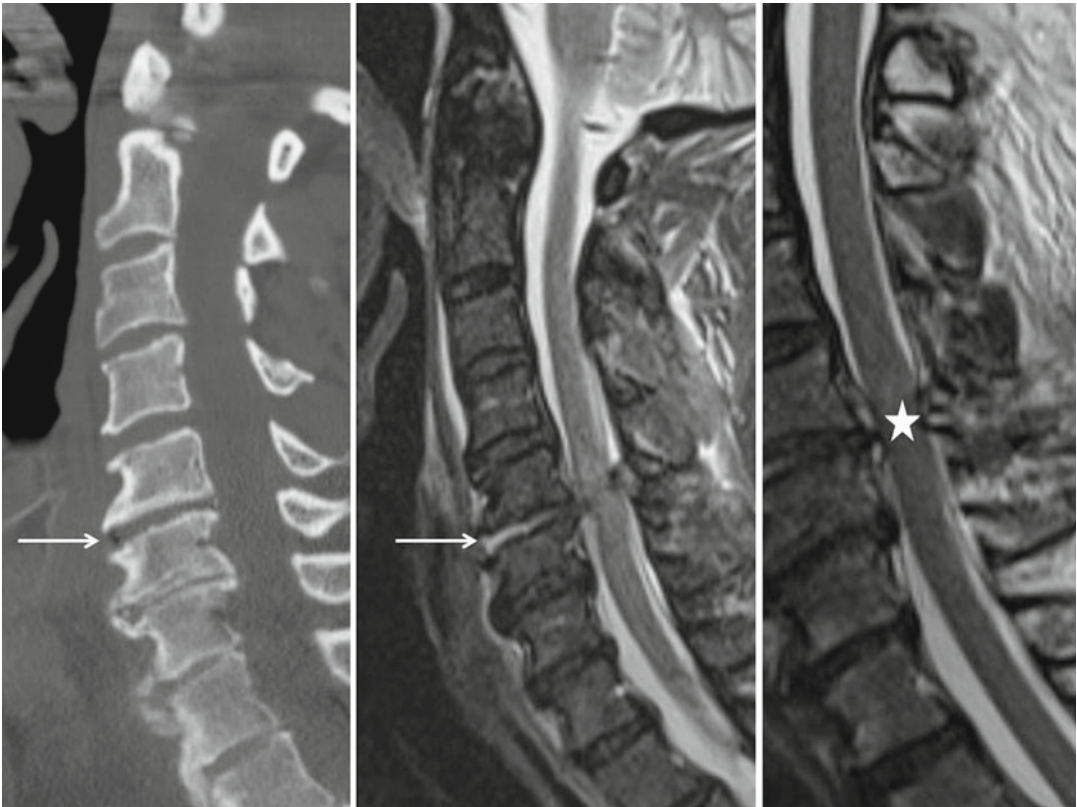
Midsagittal computed tomography (CT) image (*left image*) of the cervical spine demonstrating maintained alignment and significant spondylosis. The only hint of an injury is the air diskogram at C5–6 (*arrow*). However, considering the “pattern-of-injury” in this patient, one develops much more concern. A fall from height with significant force impacting the facial region (multiple facial abrasions, lacerations, and a nasal bone
